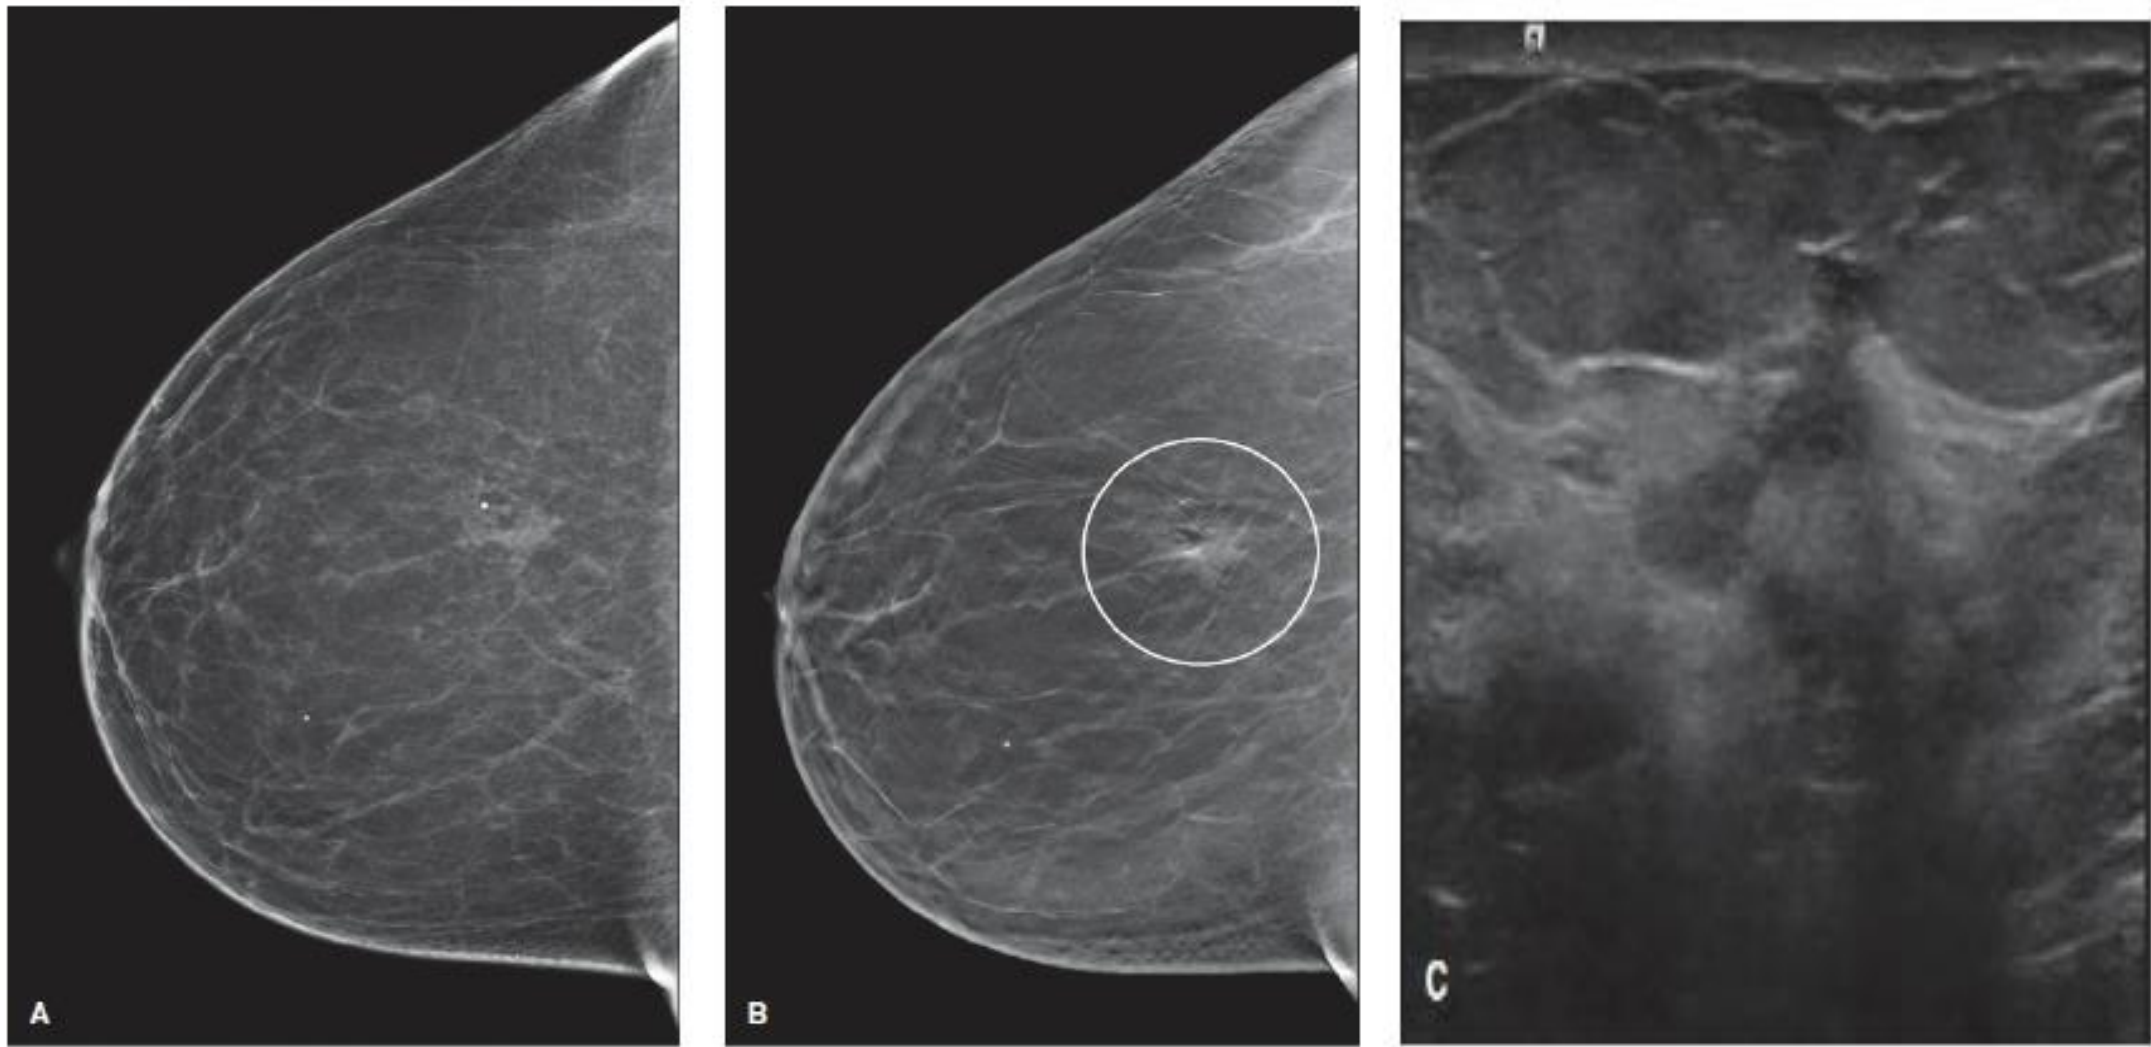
Tomosynthesis in Diagnostic Examination. A: Screening right CC identifies a developing asymmetry in the posterior aspect. B: Tomosynthesis allows better visualization and characterization. The finding now appears as an irregular-shaped mass with indistinct margins (circle). C: Ultrasound confirms an irregular-shaped mass. Biopsy revealed IDC.
